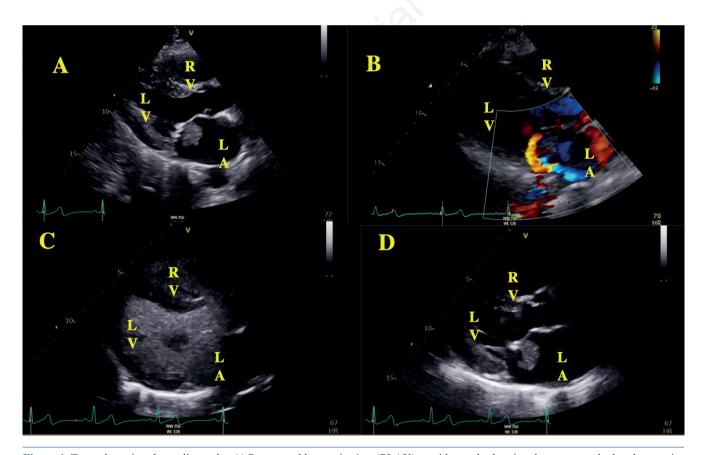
Trans-thoracic echocardiography. A) Parasternal long axis view (PLAX) at mid-systole showing the mass attached to the anterior mitral leaflet; B) PLAX, systole, color doppler at mitral valve showing posteriorly directed jet of mitral regurgitation; C,D) baseline contrast-enhanced echocardiography by Optison showing left ventricular opacification and no uptake of contrast the mass (baseline) (C) and 20 minutes after the contrast (D). LV, left ventricle; LA, left atrium; RV, right ventricle.
